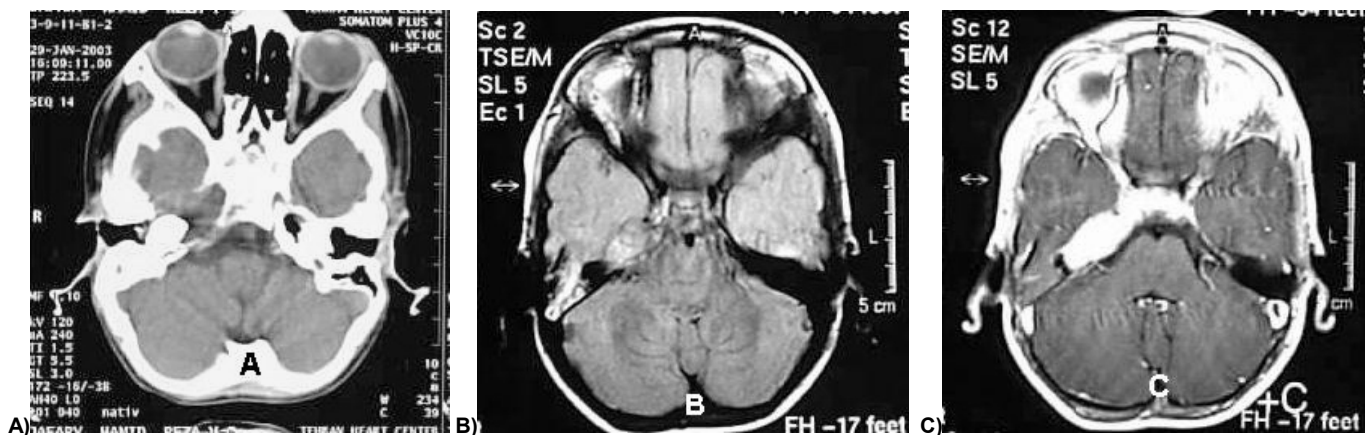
A) Plain CT scan: Tumoral lesion with erosion of the apex of the temporal bone and extension to the eustachian tube. B) Axial T₁-WI MRI: The tumor reaches the cavernous sinus and internal auditory canal. C) Axial enhanced MRI: Intense enhancement is noted in the tumor and adjacent meninge.
